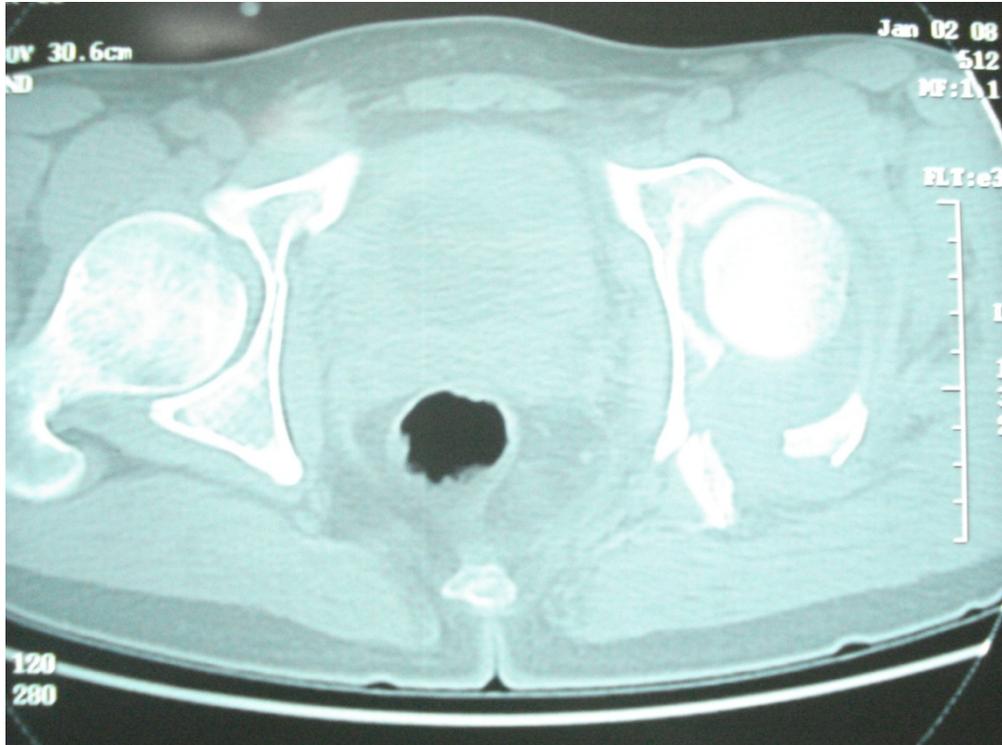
CT Scan of same patient.
